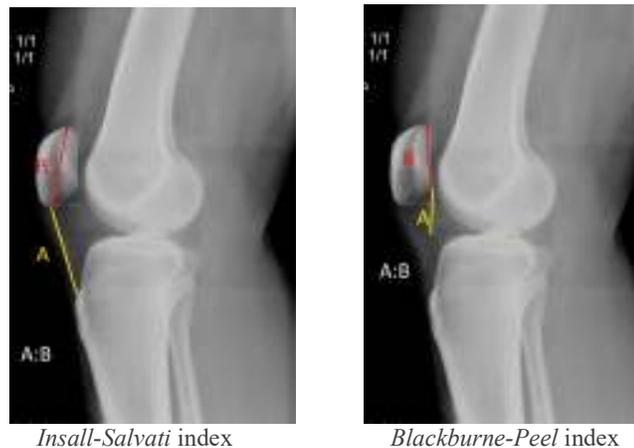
Defining *Insall-Salvati* and *Blackburne-Peel* indices by radiographs
